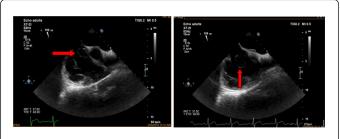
Image of transo-esophageal echocardiography showing a hyperechoic mass, mobile, serpentiform (Chiari network highly developed) arrow.
